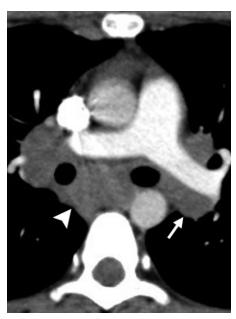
PTLD in an 18-year-old woman 4 months after allogeneic HSCT for severe aplastic anemia. Axial enhanced CT image obtained with mediastinal window settings shows enlarged subcarinal (arrowhead) and bilateral hilar (arrow) lymph nodes. The donor stem cells were proved to be infected with Epstein-Barr virus.
